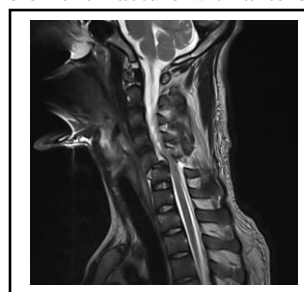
T2-weighted magnetic resonance imaging sagittal view, showing subluxation of C5 over C6 (about 50% anterior translation) causing spinal canal narrowing and spinal cord compression.
